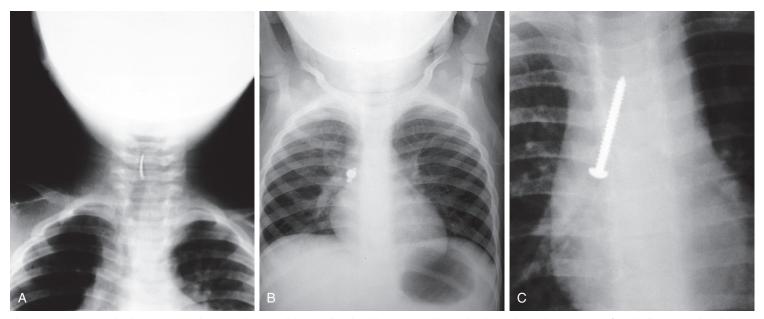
Foreign body aspiration. Radiopaque objects and those well outlined by air are readily visualized on radiographs. A, A piece of eggshell is seen in the subglottic portion of the trachea, clearly outlined by the air column. B, An earring lies in the entrance of the right mainstem bronchus. C, A screw is seen lodged in the right mainstem bronchus and projecting into the trachea. (A, Courtesy Mananda Bhende, MD, Children's Hospital of Pittsburgh, Pittsburgh, Pa.; B and C, courtesy Robert Gochman, MD, Schneider Children's Hospital, Long Island Jewish Medical Center, New Hyde Park, N.Y.)
